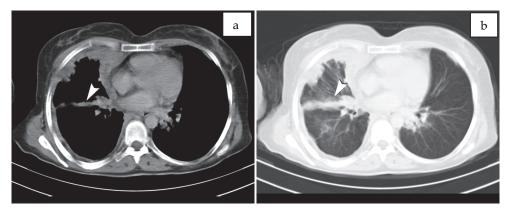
Axial contrast enhanced CT mediastinal (a.) and parenchymal sections (b.) shows right sided irregular pleural thickening and right major fissur involvement (arrow head).
